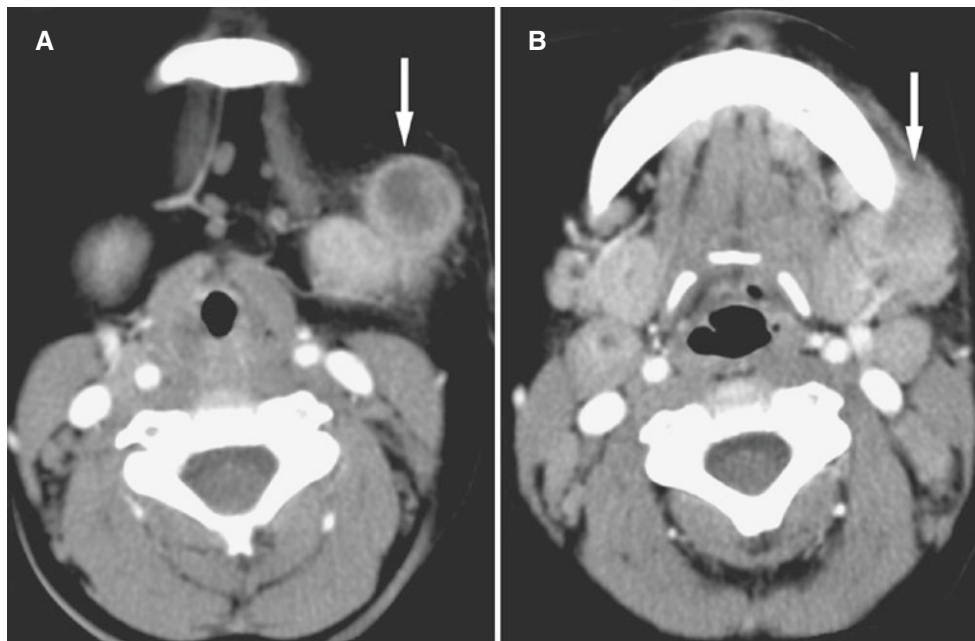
Abscess, submandibular; 22-month-old male with history of left neck mass, strep throat, and fever. (A) Axial post-contrast CT image, soft-tissue window, shows anterior and lateral to left submandibular gland a hypodense nodular, circular structure surrounded by
